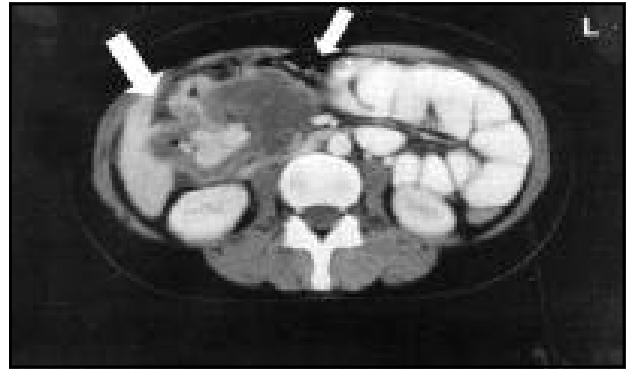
Computed tomography of the abdomen demonstrating a transverse colonic mass infiltrating the adjacent visceral surface of the liver and the second part of the duodenum (arrows).
